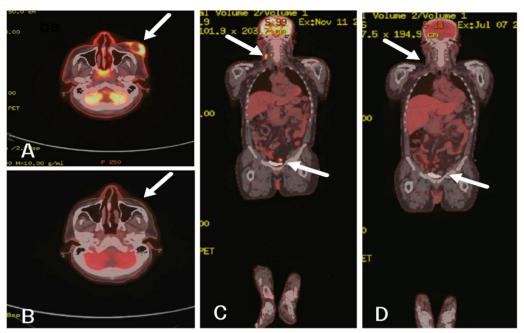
A, B Axial PET-CT increased tracer uptake left facial lesion (arrows) and complete resolution of same post treatment respectively. C, D coronal PET-CT, increased tracer uptake in cervical and inguinal lymph node (arrows) and complete resolution of same post-treatment
